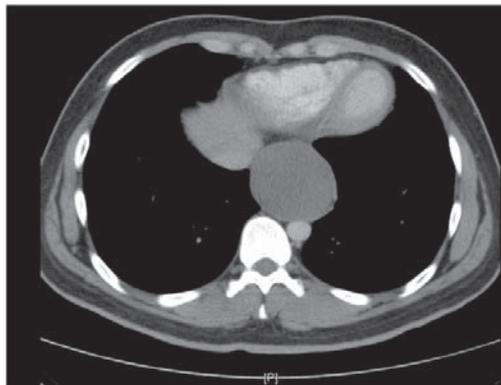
CT scan of the lower thoracic region showing the cyst effacing the distal oesophagus (axial view).
